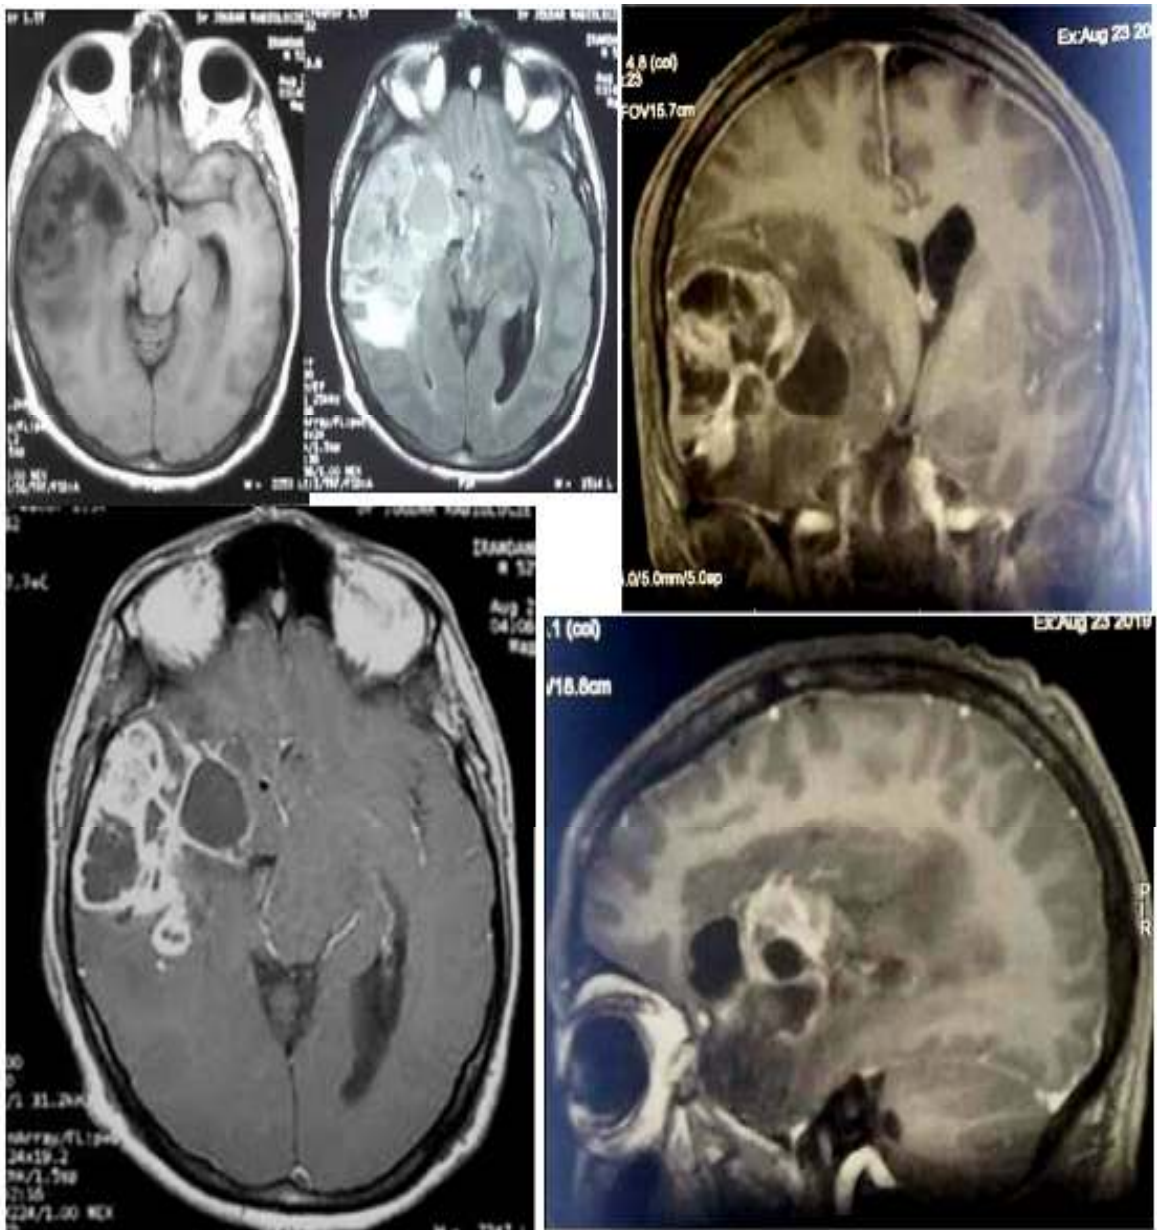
preoperative MRI on T1WI without and after gadolinium, FLAIR and T2WI showing the huge right-side temporal glioblastoma.
